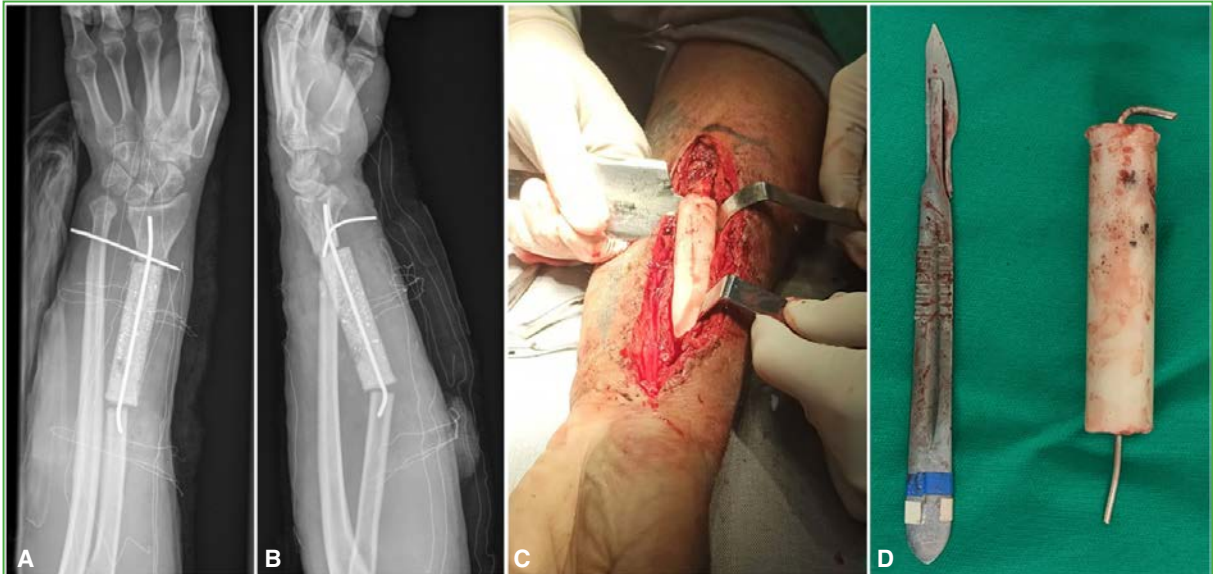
Anteroposterior (A) and lateral (B) radiographs of the forearm in the immediate postoperative period, showing orthopedic cement associated with Kirschner wires. C and D. Visualization and placement of orthopedic cement.
